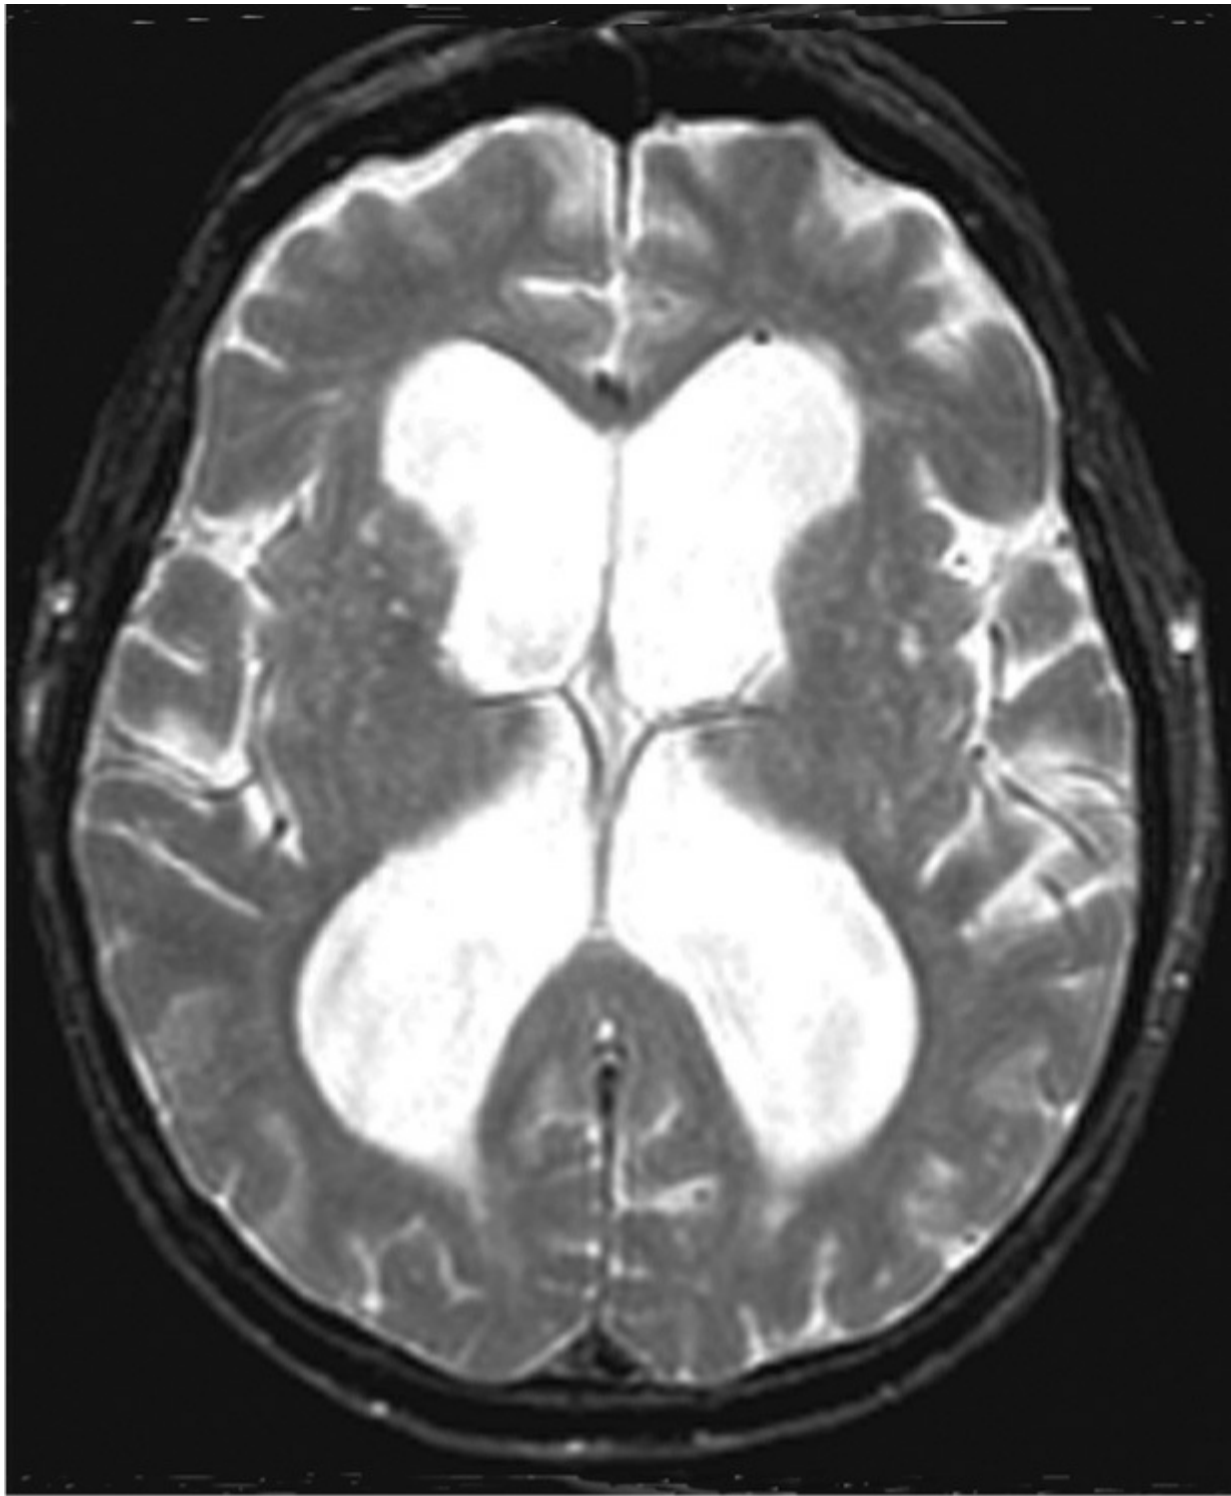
Normal-pressure hydrocephalus magnetic resonance image (MRI). Axial T2-weighted MRIs demonstrate dilation of the lateral ventricles. This patient underwent successful ventriculoperitoneal shunting. (Reproduced, with permission, from Longo et al. *Harrison's Principles and Practice of Internal Medicine*. Vol 2, 18th ed. New York: McGraw-Hill; 2012.)
